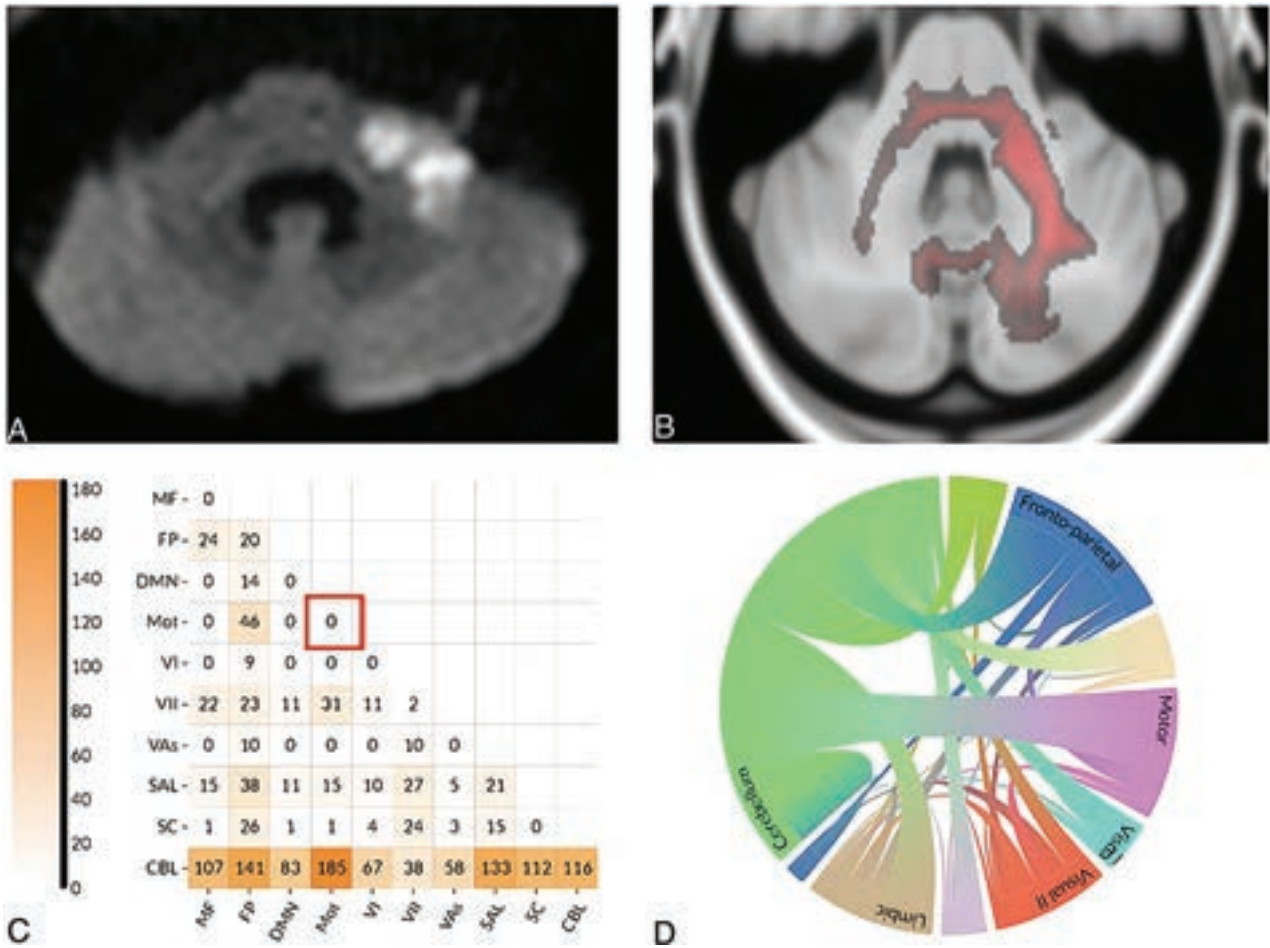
Representative case of a 62-year-old man with left middle cerebellar peduncle ischemic infarction. He did not have poststroke dysphagia, and the model also predicted negative results. *A*, Substantial infarction volume in DWI. *B*, Disconnected tract attenuation map (red) due to infarction. Nonetheless, the disconnection is mostly distributed in the cerebellar network, with no disconnection within the motor network (*C*, red square; *D*), which may be preventing the patient from poststroke dysphagia.
